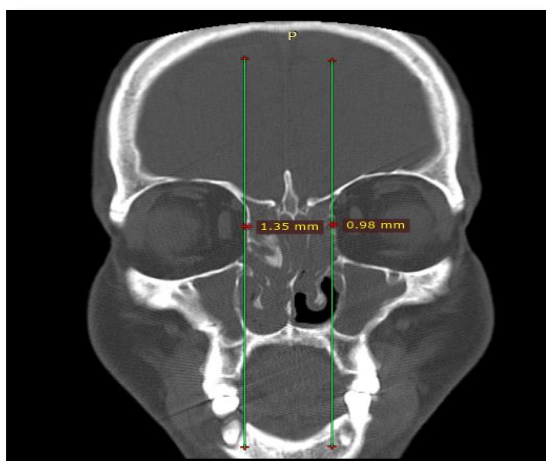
coronal CT showed on the right side grade 4 polyposis and LP type 1 while on the left side showed grade 3 polyposis and LP type 1 .
